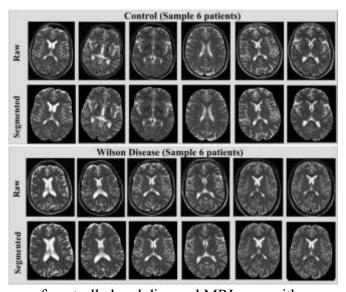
Sample images of controlled and diseased MRI scan with corresponding segmented images (skull stripping).
